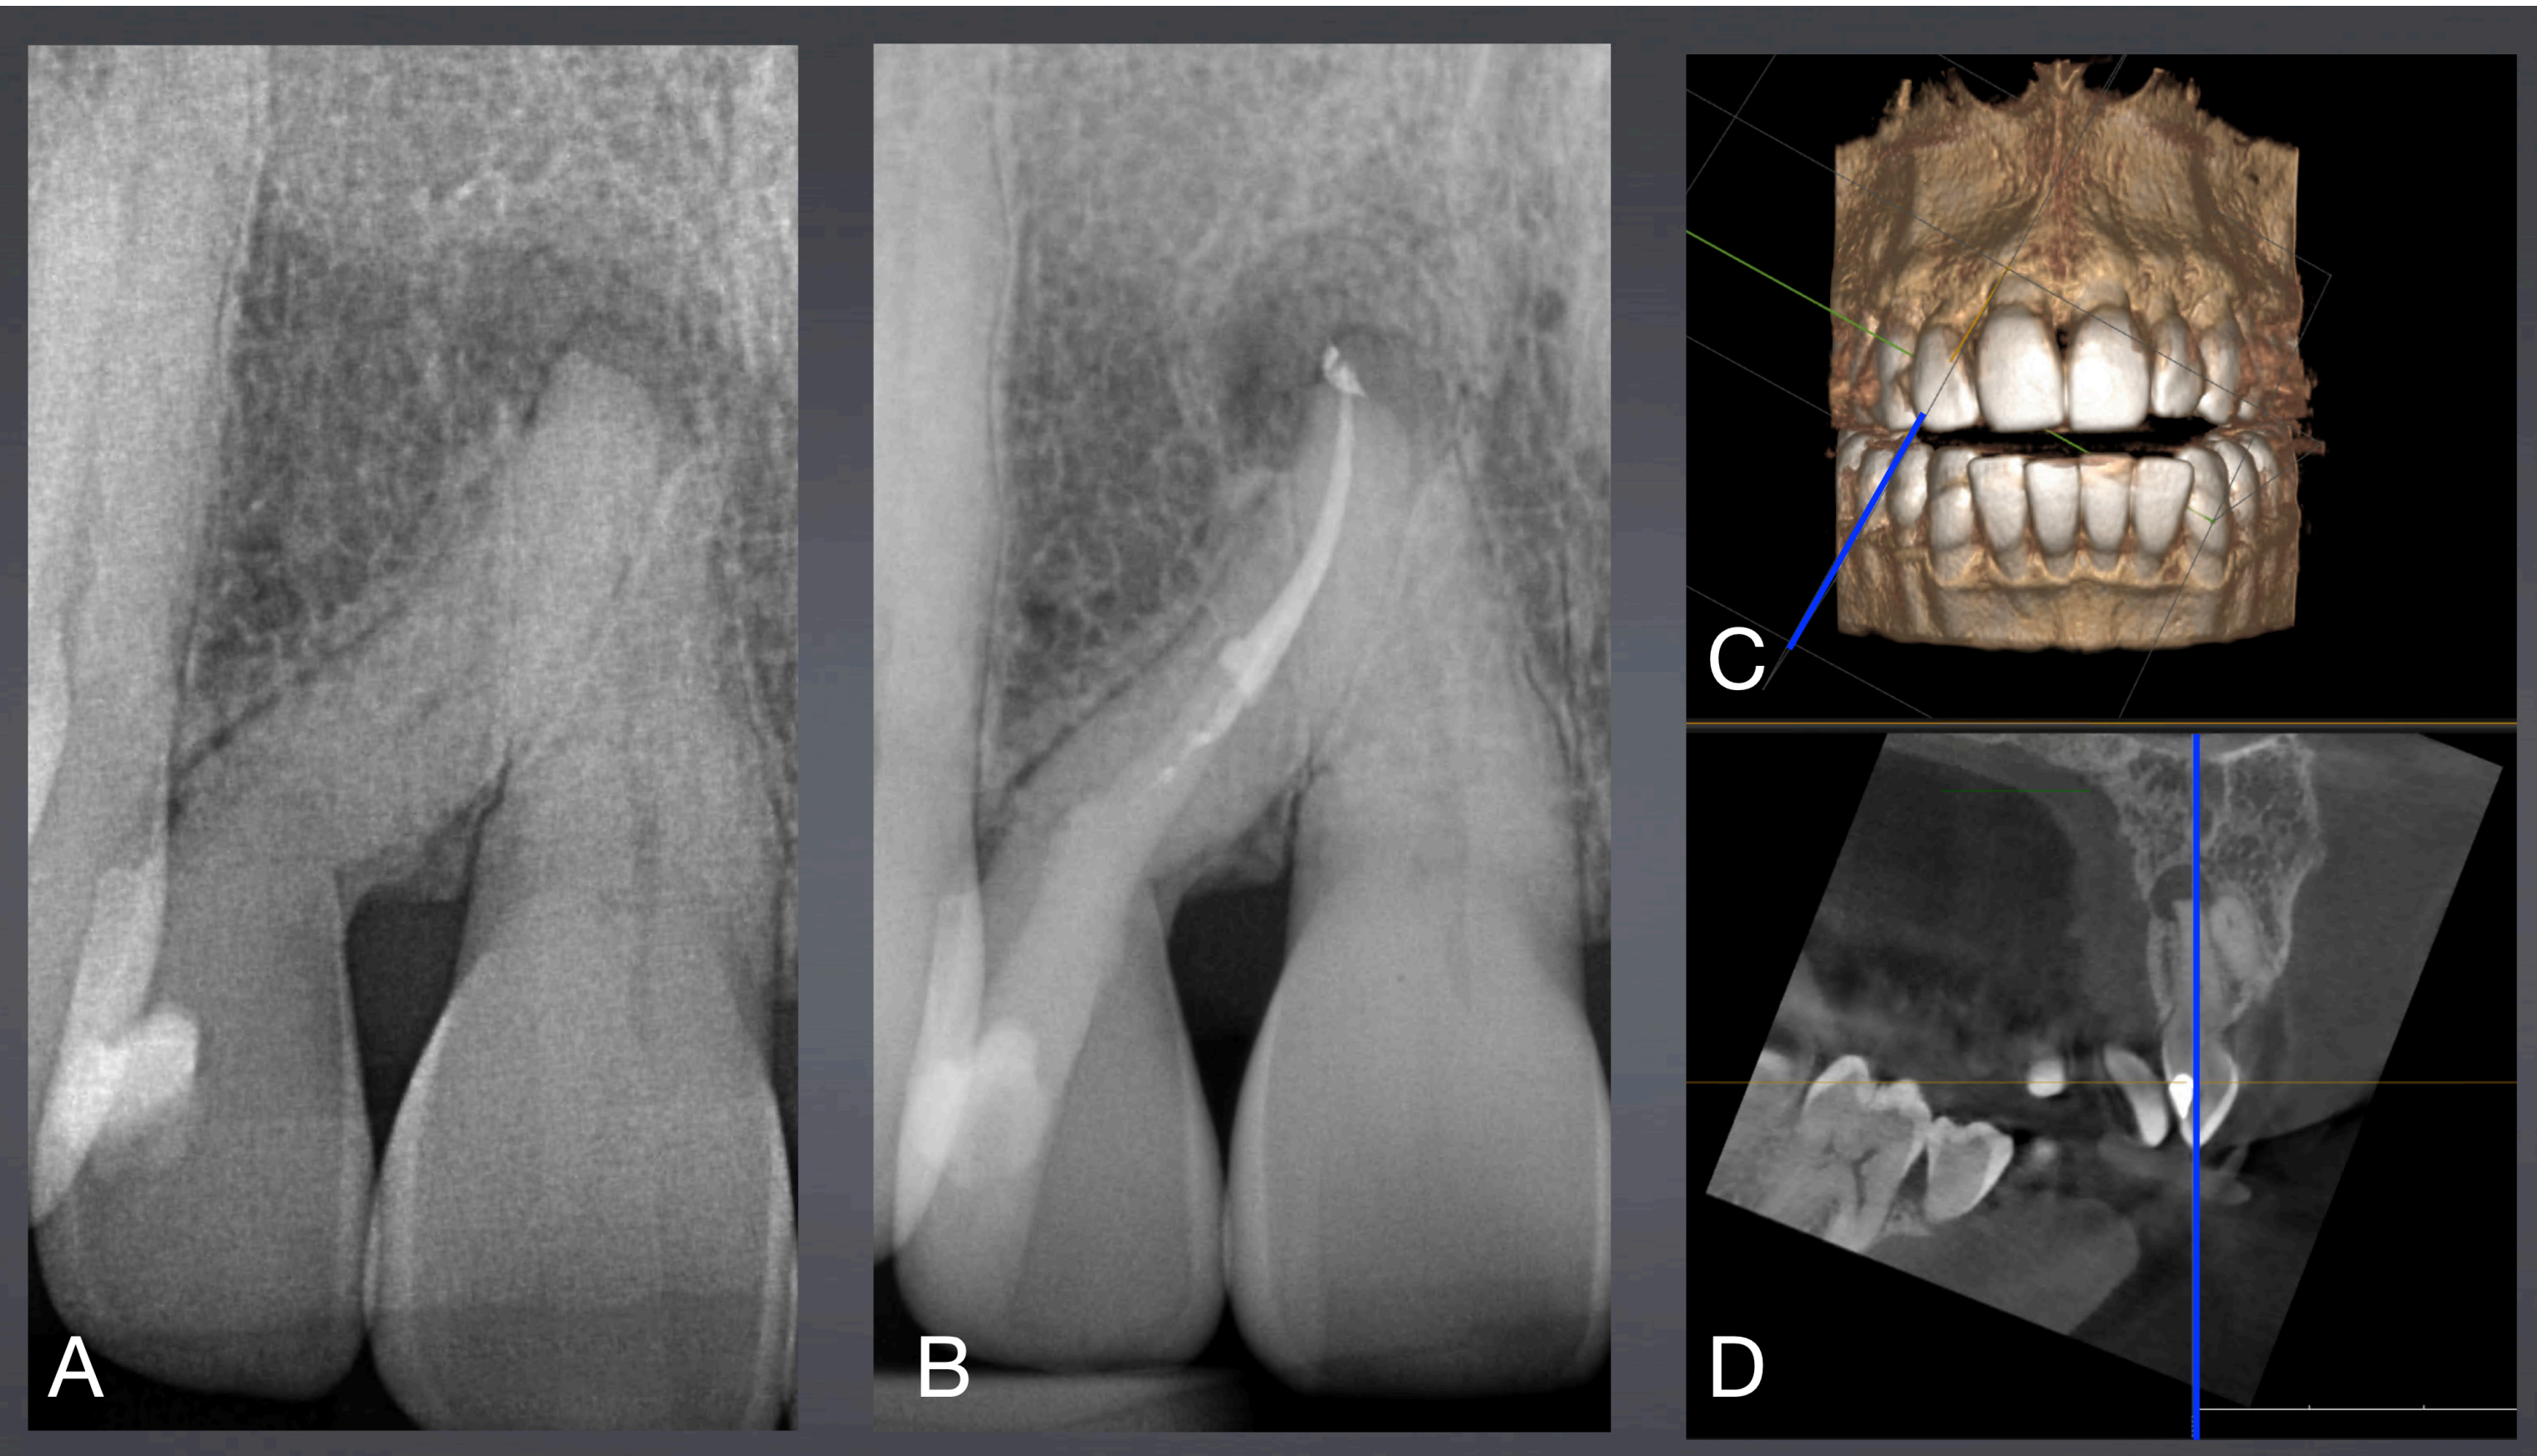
A: Upper lateral incisor (12) with 45° dilaceration. B: successful obturation of the root canal system avoiding root perforation. C+D: Access entry and cavity preplanning using CBCT imaging and SicatEndo software approach.
